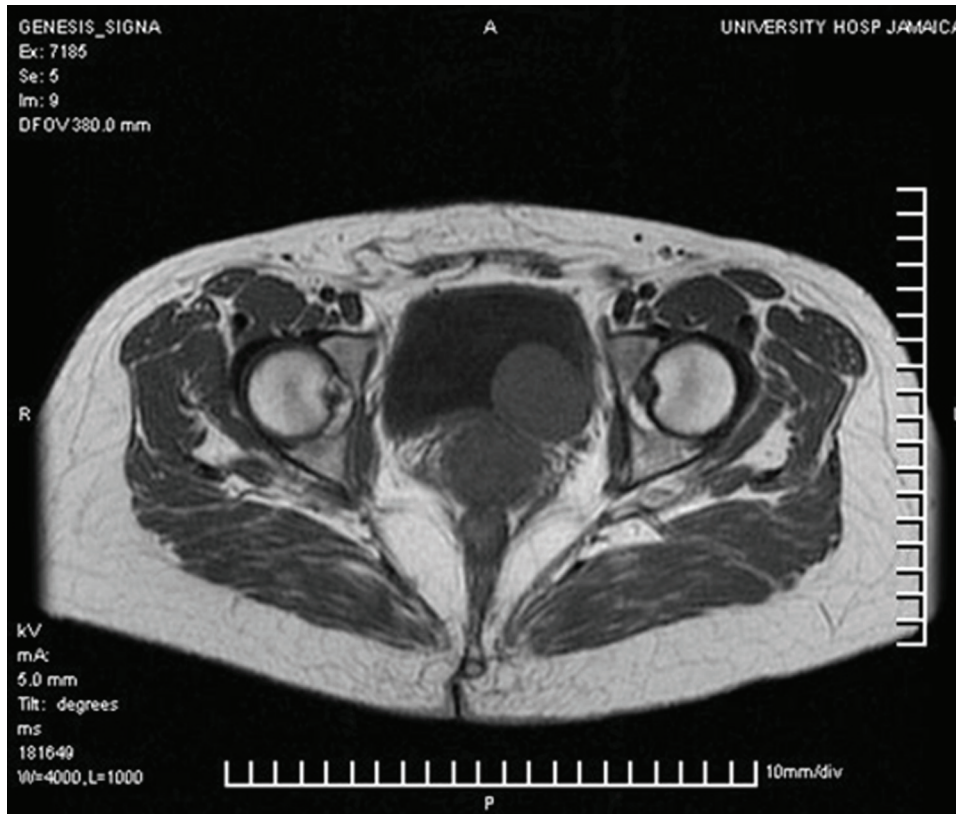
Axial T1-weighted MRI of pelvis.
